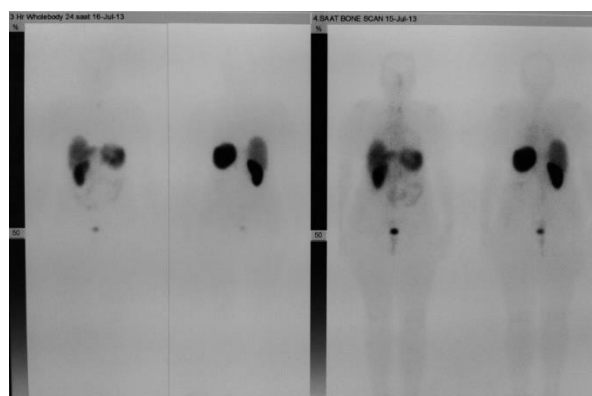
Postoperative scintigraphic image of the patient
